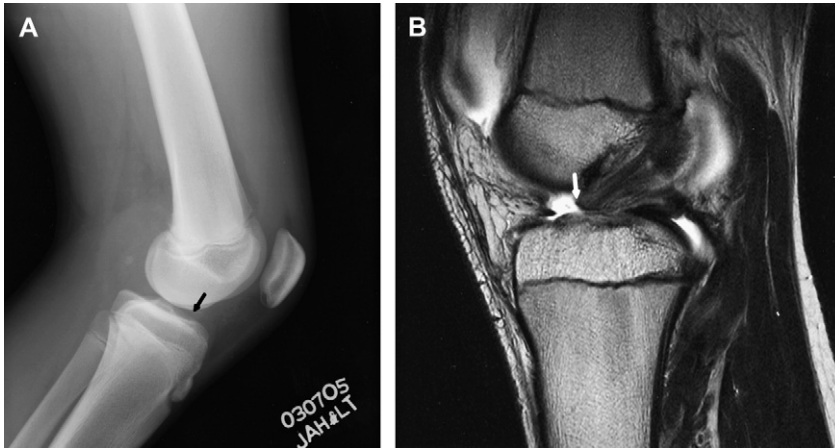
Type III tibial eminence fracture. Lateral radiograph (A) and T2-weighted sagittal MR image (B) demonstrate a subtle eminence avulsion (black and white arrows).
